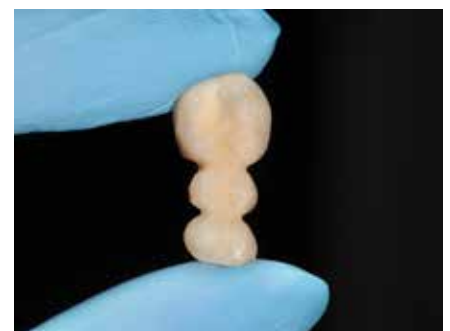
Temporary bridge made with TEMPSMART DC
